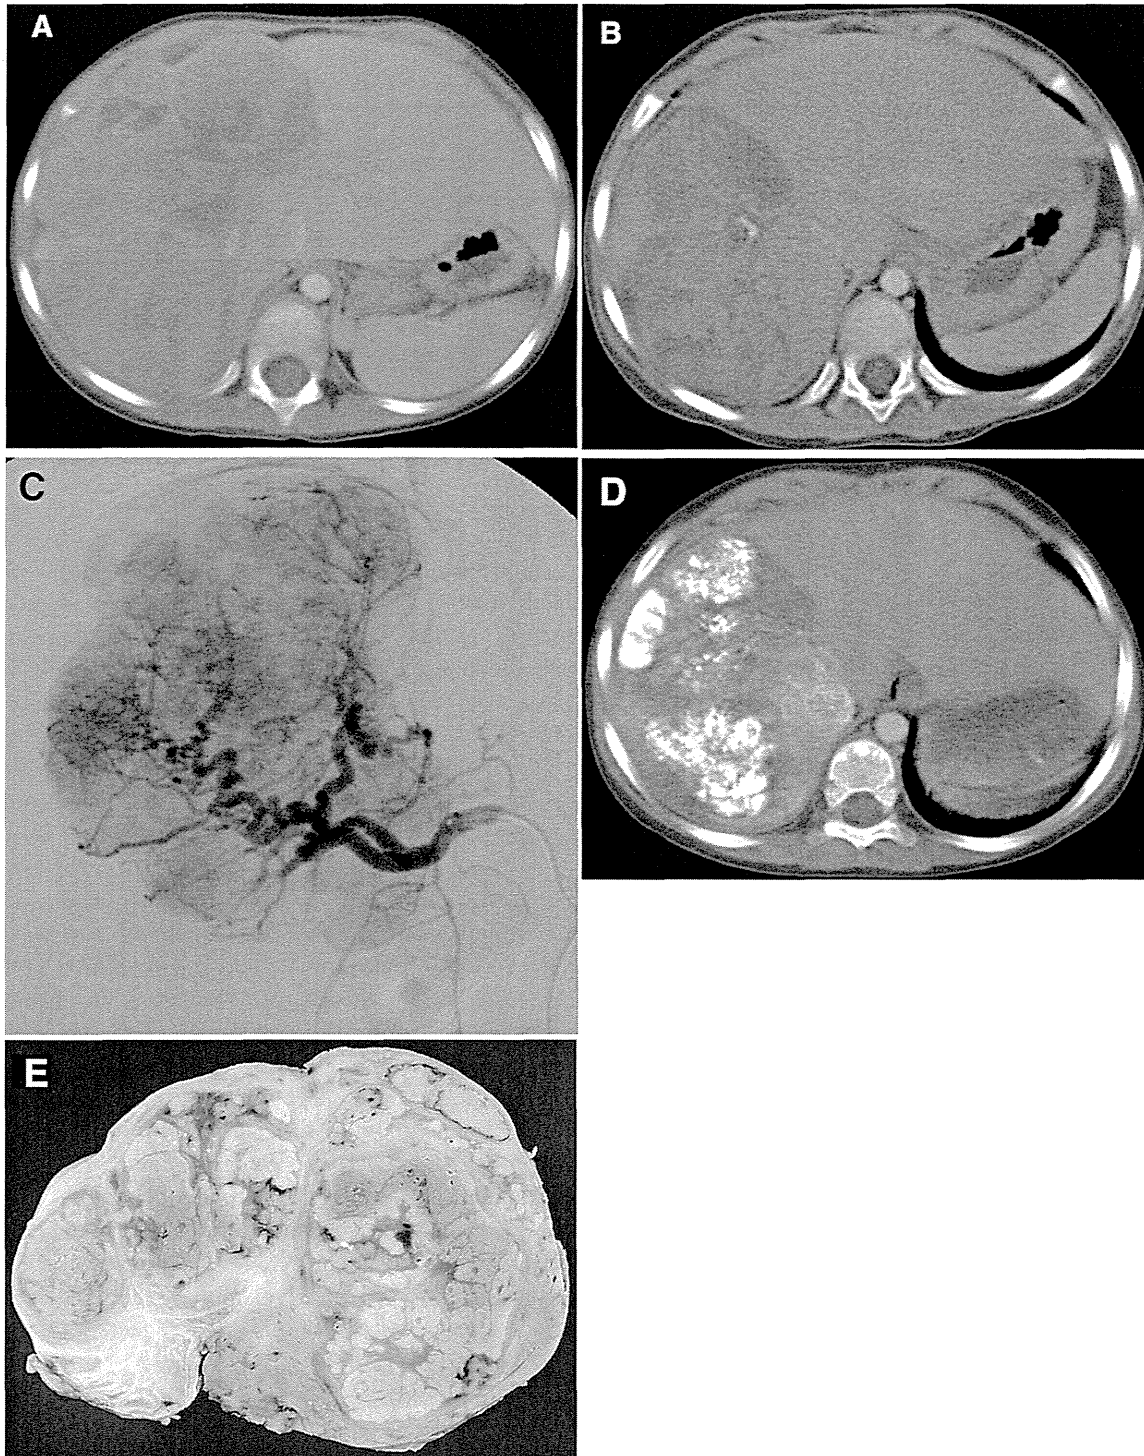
38-month-old boy with poorly differentiated hepatoblastoma (case 6). Tumor size 11 × 6.4 cm, AFP 30,416 (ng/mL), PRETEXT II. a Enhanced CT before treatment reveals a large tumor involving almost the entire right lobe and S4. b Enhanced CT after CITA 4 kur. Tumor volume decreased by 21.2 %. c Pre-chemoembolization angiogram via the hepatic artery shows a large hypervascular lesion
